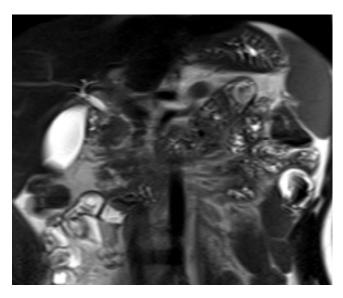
Coronal T2 weighted MR image shows that the biliary ducts are not dilated and only the pancreatic head is seen.
